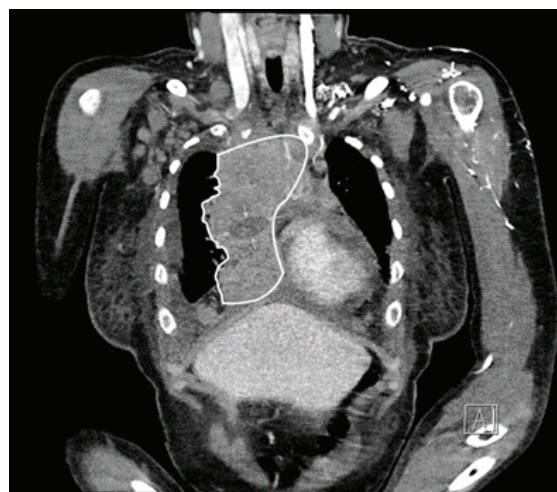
CT image of mediastinal mass outlined in white and necrotic centre (grey arrows).
